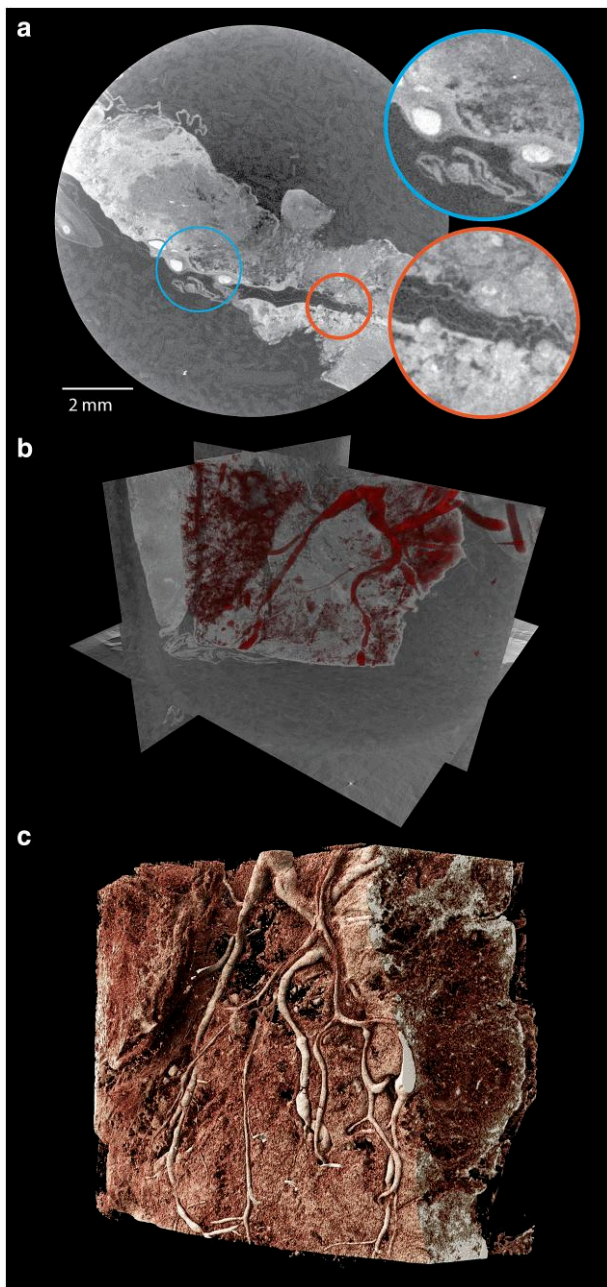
Laboratory scan of entire healthy human placenta (same placenta as shown in Fig. 2). a) Slice showing placental tissue, reconstructed from a laboratory μ CT scan, with zooms into vasculature and amniotic membrane on the fetal side of the placenta. b) 3D visualization with three orthogonal slices through the volume and rendering of the vascular tree (Avizo 3D, Thermo Fisher Scientific, Waltham, USA). c) Cinematic rendering of the dataset, highlighting the fetal side of the placenta.
